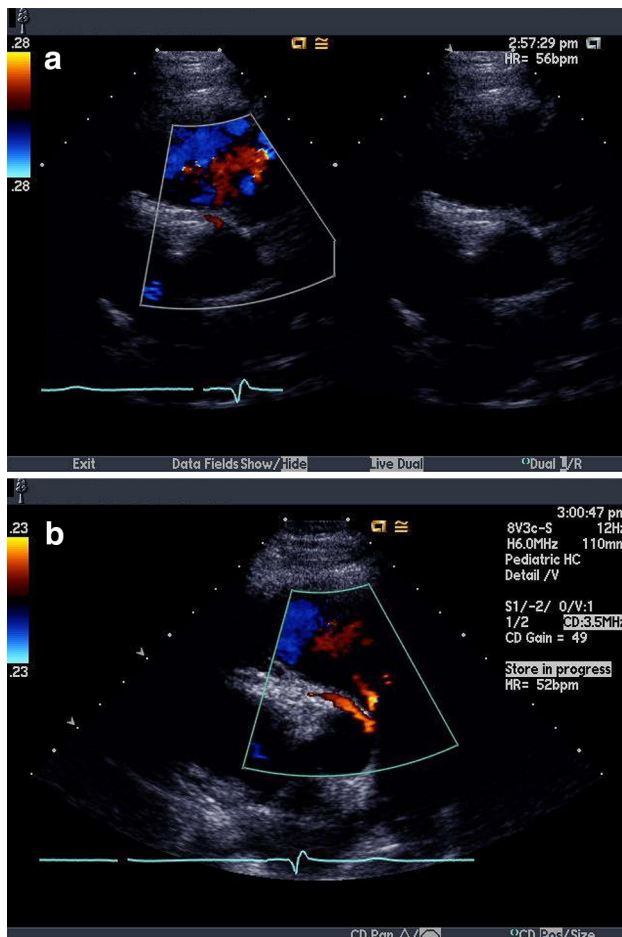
False negative in a different patient with anomalous right coronary artery when imaged in the a standard parasternal short axis view; the anomalous coronary is visualized more superiorly (b)
